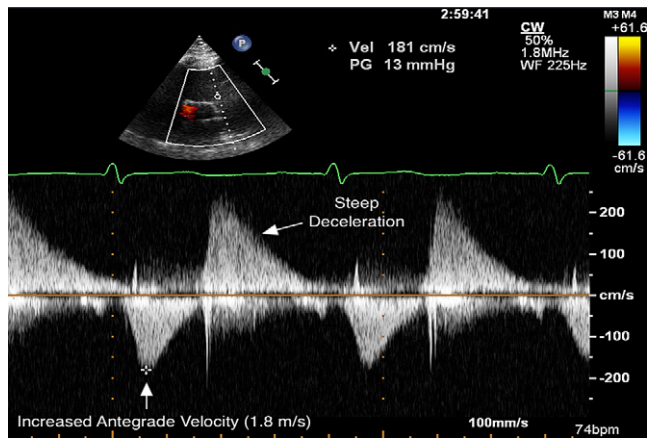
Continuous-wave Doppler through the pulmonic valve obtained by transthoracic echocardiography shows increased antegrade velocity through the pulmonic valve. Steep deceleration of PI signal is also noted.
